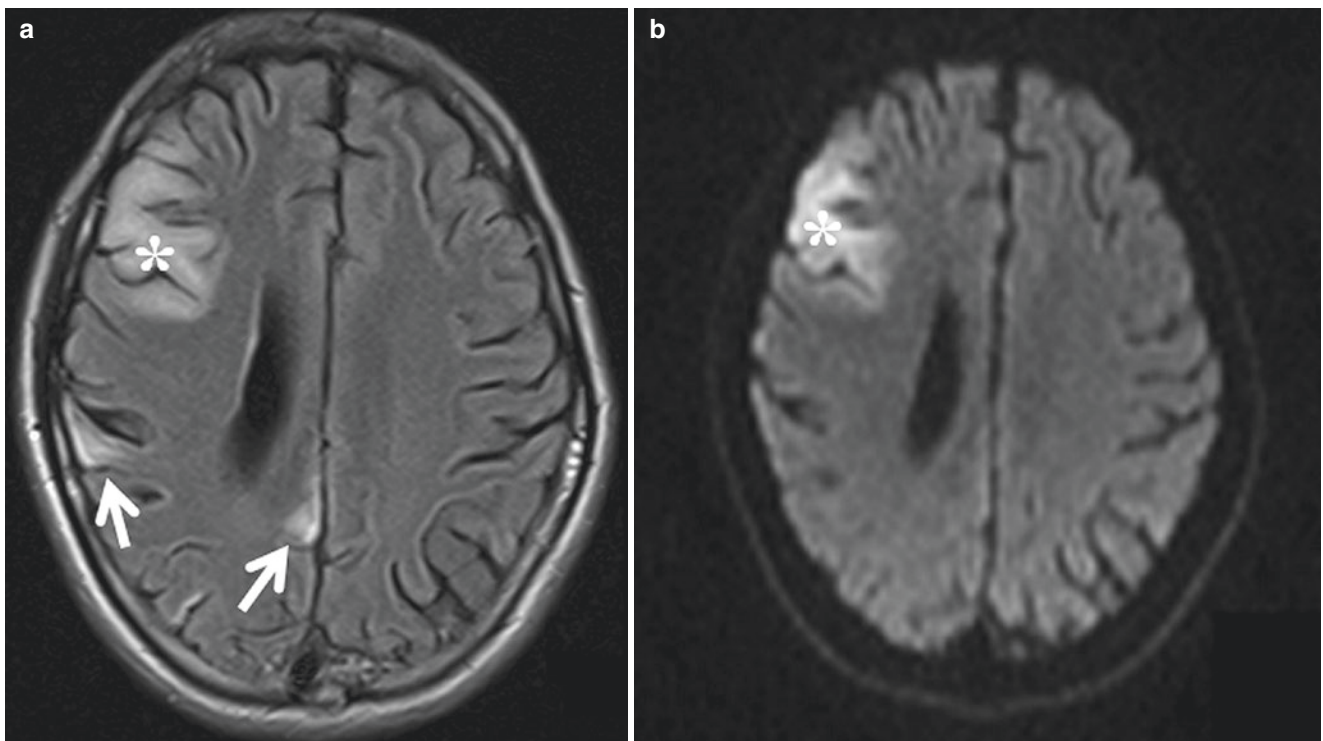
Mitochondrial myopathy, encephalopathy, lactic acidosis, stroke-like episodes (MELAS). Ten-year old presents with recurrent strokes and seizures. (a), Axial FLAIR image shows multiple cortical
